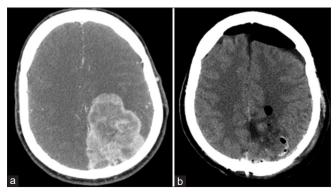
(a) The lesion on an axial section of the preoperative computed tomography (CT) scan with contrast matter; (b) Postoperative CT head scan showing the subtotal resection of the lesion and postoperative pneumocephalus, which was asymptomatic.
